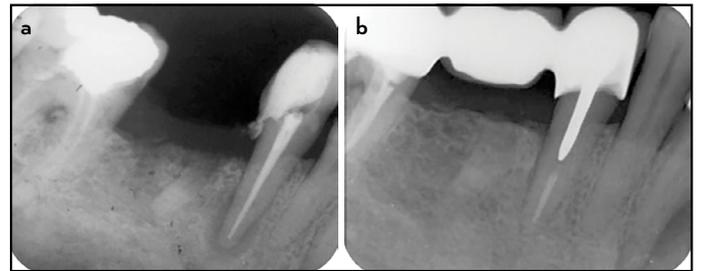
a-b. Images of a mandibular right first premolar classified as "healed" following endodontic treatment. (a) The post-operative radiograph shows periapical radiolucency around the apex. (b) The 4-year follow-up radiograph shows complete resolution of periapical radiolucency
